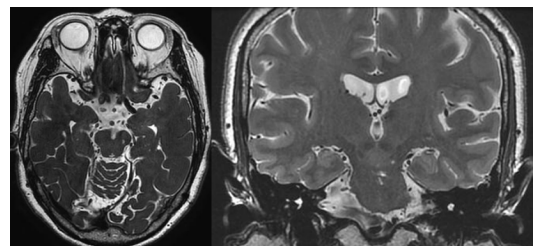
Magnetic resonance imaging (MRI) 7 years after surgery showed no interval change compared with previous images.
